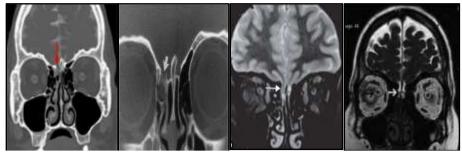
1. HRCT images of CSF Rhinorrhea.
